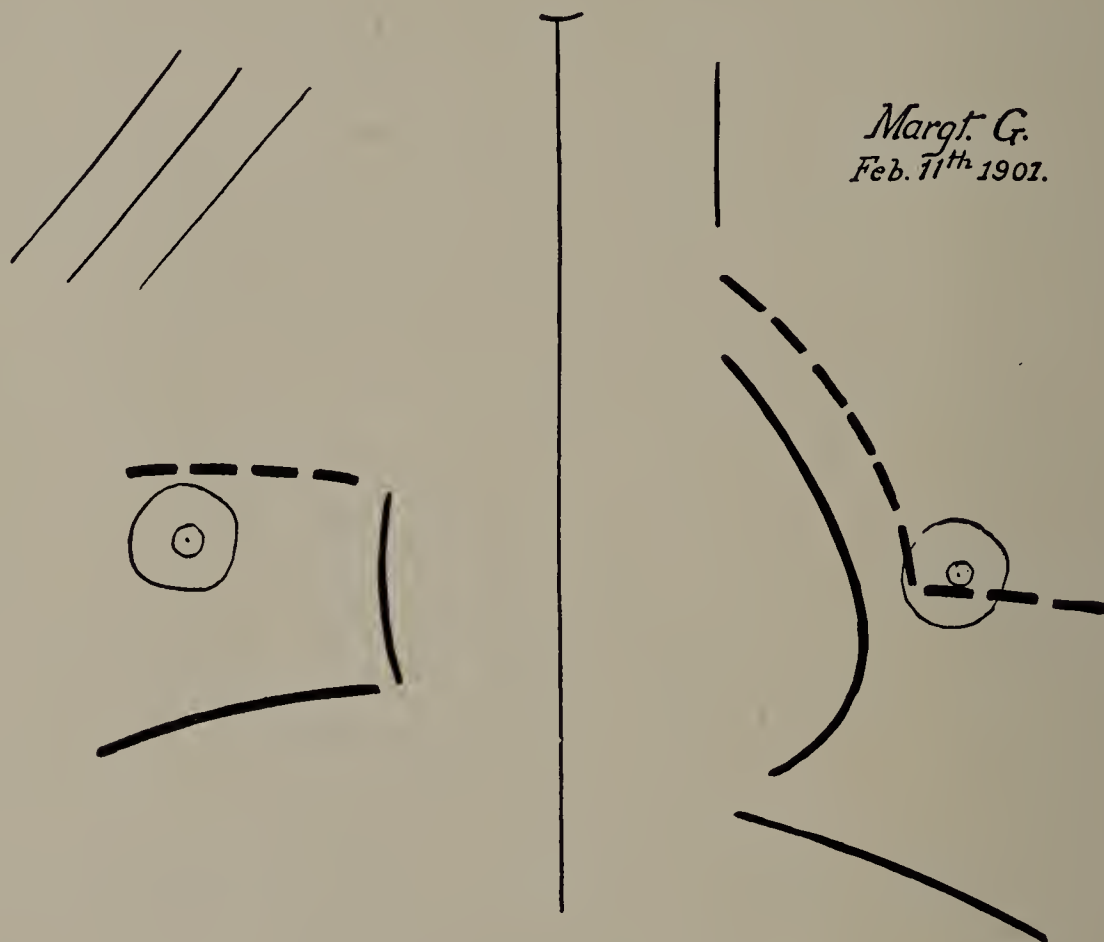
Margaret G. Returned to the Adirondack Sanitarium in June and remained there four months more; she came back in excellent condition. My last X-ray examination, with screen, February, 1901, gave the above results. (One-third life size.)
